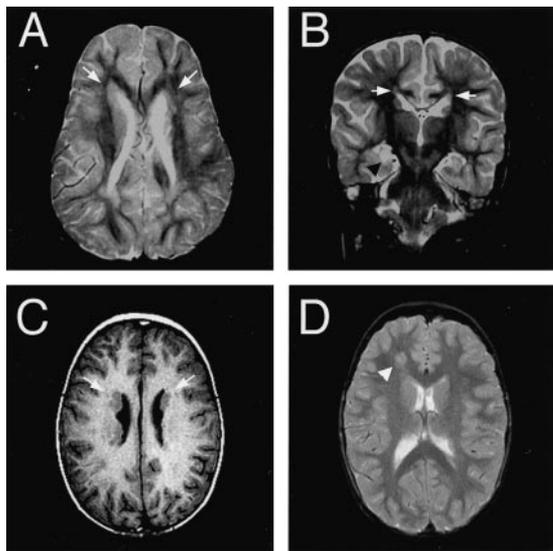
Brain MRI appearance of patients with periventricular heterotopia (PH) associated with trisomy for distal chromosome 5p. (A) Axial T2-weighted image from Proband 1 demonstrates nodular areas of heterotopic gray matter adjacent to the frontal horns of the lateral ventricles bilaterally (white arrows). (B) Coronal T2-weighted image of same patient in (A) shows bilateral periventricular heterotopia (white arrows) and an area of abnormally increased T2 signal in the right hippocampus (black arrowhead) consistent with hippocampal sclerosis. (C) Bilateral noncontinuous heterotopia (white arrows) can similarly be appreciated in Proband 2 on the T1-weighted axial image. (D) Axial T2-weighted image shows the additional finding of a right frontal subcortical heterotopia (white arrowhead).
